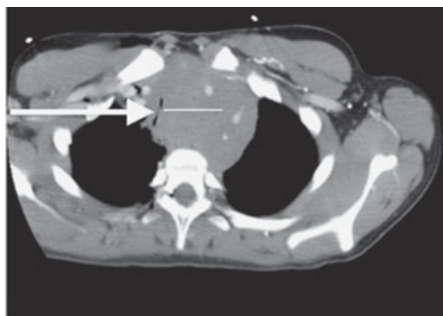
Chest CT of an anterior mediastinal mass in a teenager causing displacement and near total obstruction of the trachea (arrow).
